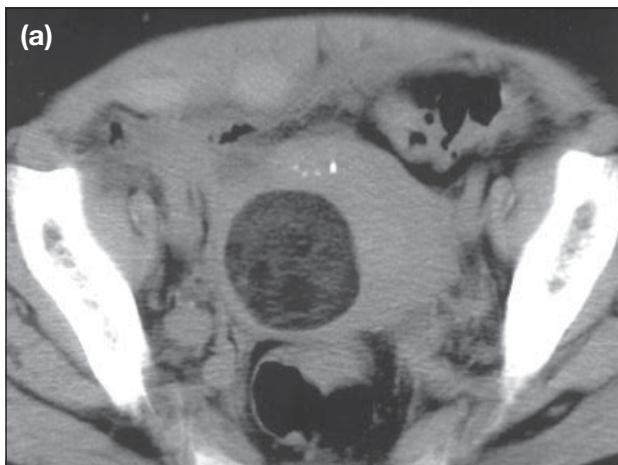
Pre- and post-contrast computed tomography scan of the pelvis shows a 'fat' density mass in the right side of the uterus, surrounded by a layer of myometrium (arrows). The findings are diagnostic of uterine lipoleiomyoma.
